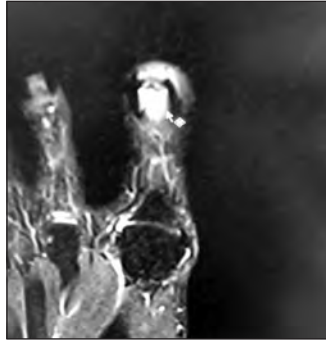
MRI contrast enhanced coronal view
